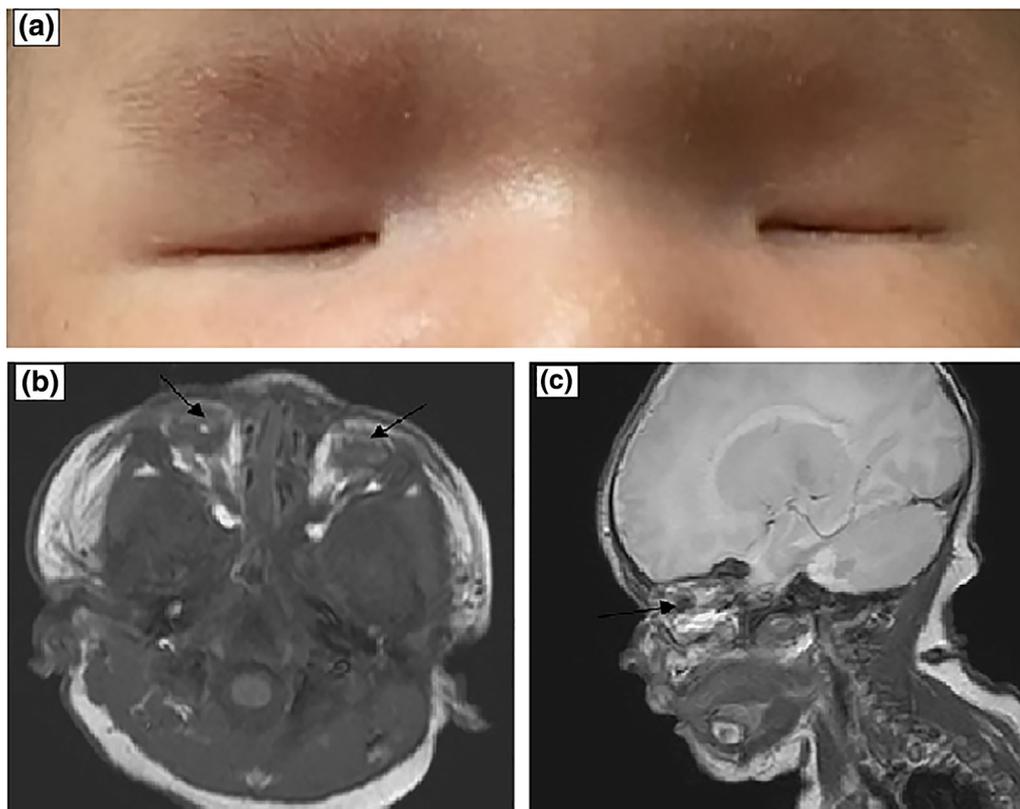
External photograph and brain MRI of the patient. (a) Bilateral clinical anophthalmia, complete fusion of the eyelid and hypoplastic sockets. (b) Axial T1-weighted image showing bilateral anophthalmia (arrows) and hypoplastic orbits. (c) Sagittal high-resolution T1-weighted image showing the anophthalmia (arrows).
